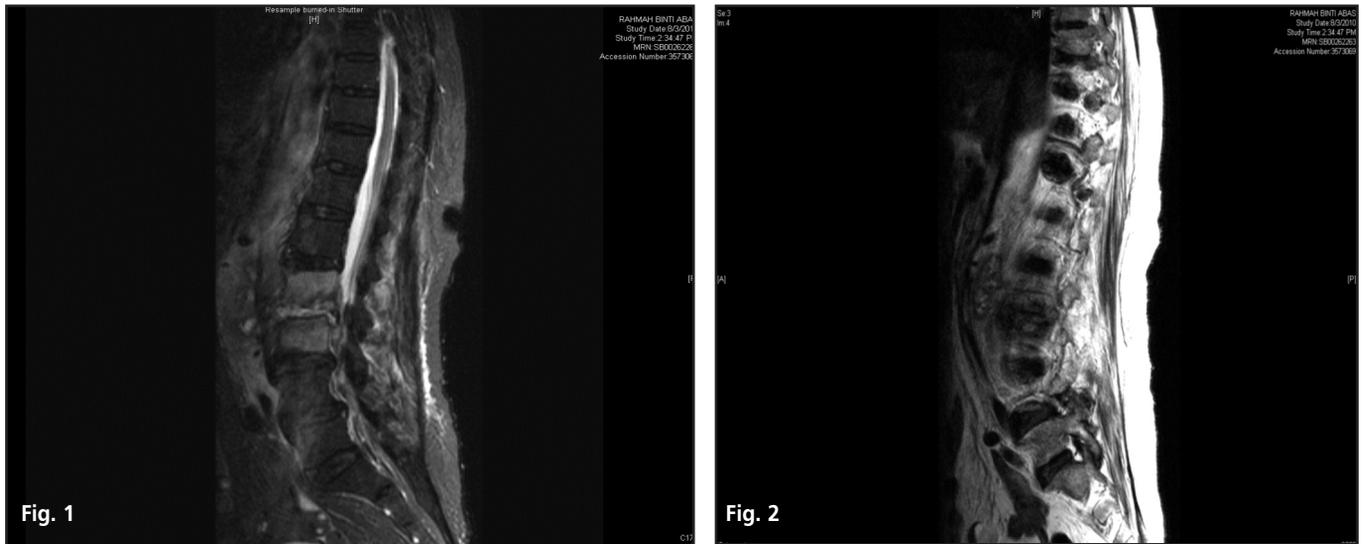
Magnetic Resonance Imaging (MRI) of the spine shows a spondylodiscitis at the L2/L3 level with large paravertebral and psoas abscesses.
